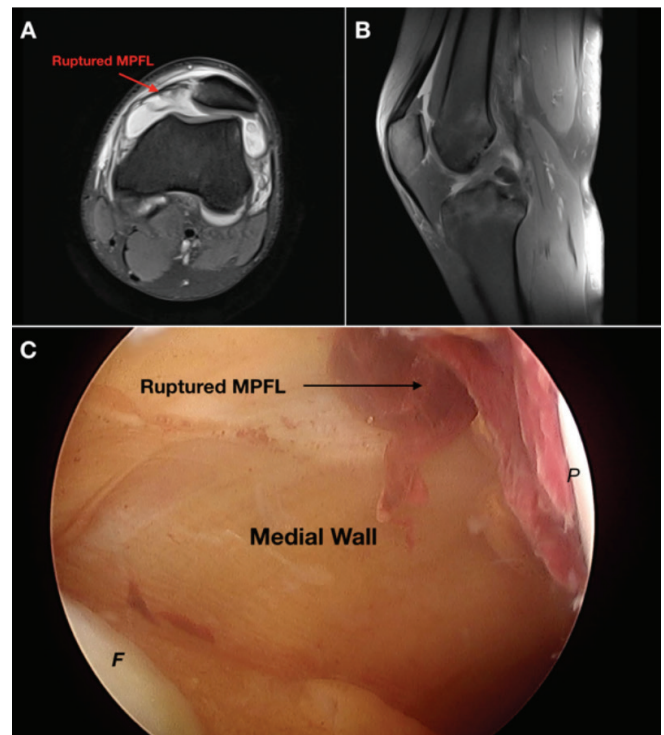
A) Axial MRI view of ruptured MPFL; B) Sagittal MRI view of injured knee and displaced patella; C) Arthroscopic view of ruptured MPFL and medial wall
